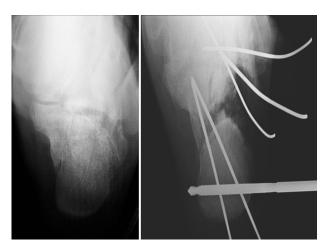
The reduction is confirmed radiographically.
